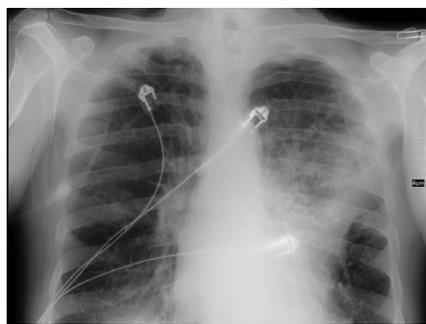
Chest X-Ray indicates cardiomegaly, interstitial oedema, and fibrotic scar from previous lung infection.
